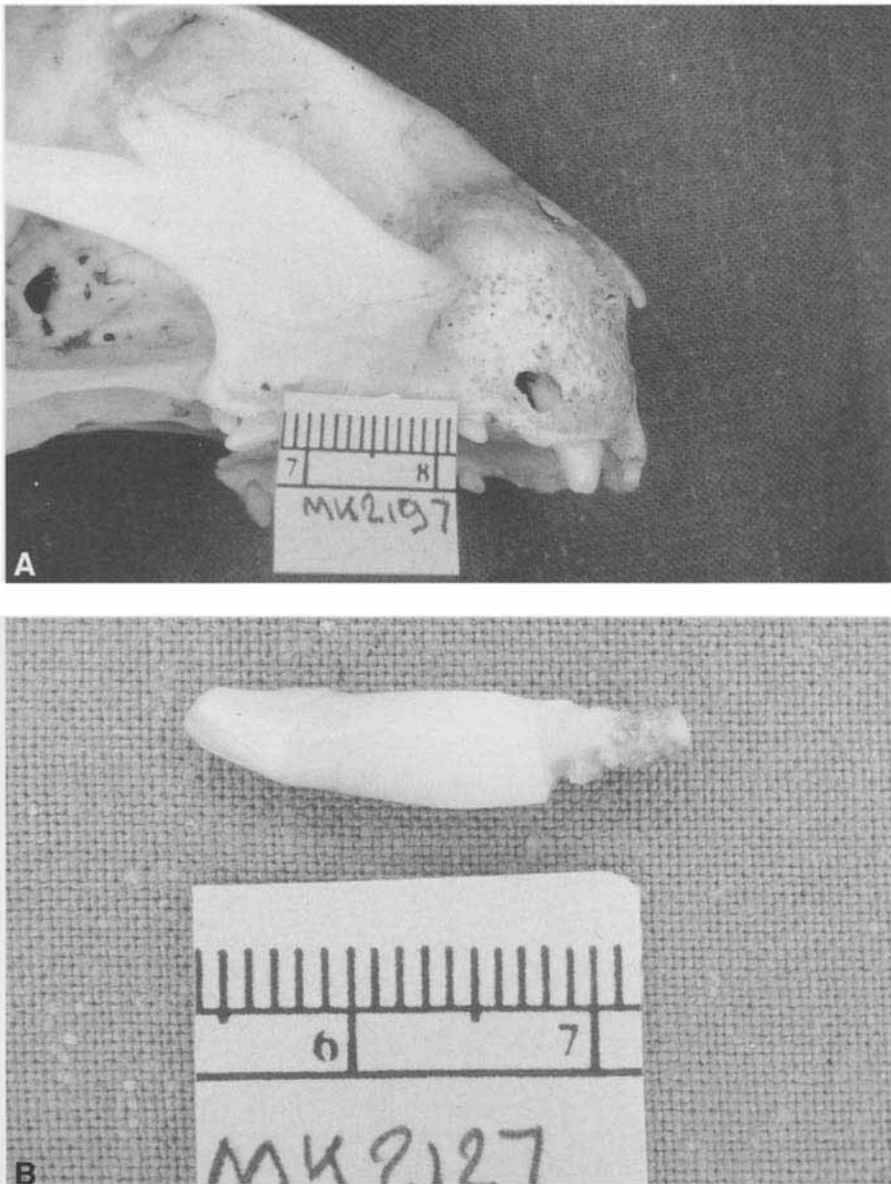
(A) Complicated crown fracture of CmaxR, with a large periapical lesion and osteomyelitis. (B) Complicated crown fracture of CmandR, with extensive resorption of the apical part of the root.
